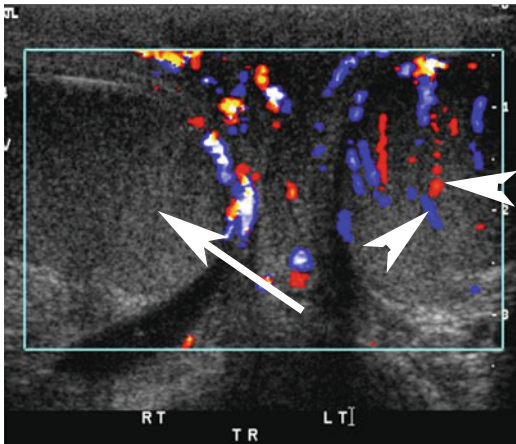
Sixteen-year-old boy who had sudden onset of right testicular pain 10 h earlier. Doppler ultrasound images of both testicles show the lack of flow in the right testicle (*arrow*), compared to the normally vascularized left testicle (*white arrowheads*). At surgery, the right testicle was found to be non-salvageable due to torsion
